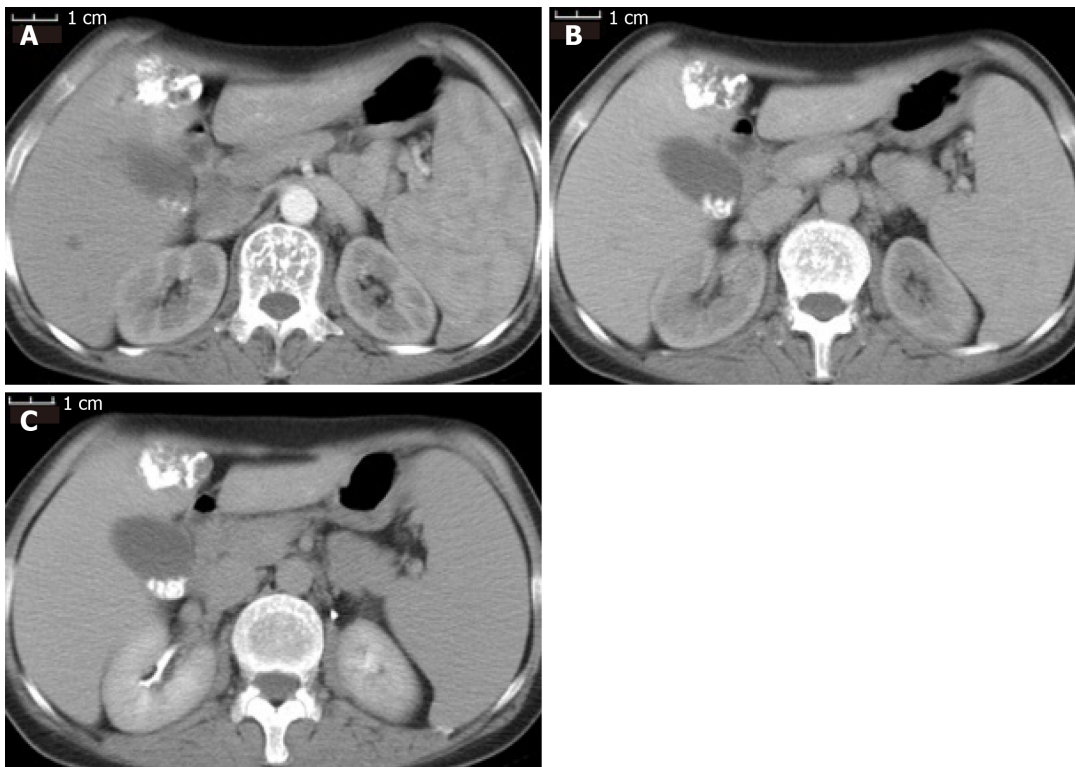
Contrast-enhanced computed tomography scan of the patient after first transarterial chemoembolization. A: Iodized oil deposition in the tumor was observed in the arterial phase; B: Portal venous phase; C: Delayed phase.
